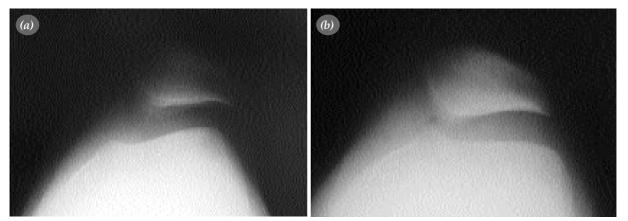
Pre-operative (a) and post-operative (b) patellofemoral axial radiographs of a patient with chronic patellar subluxation, who underwent lateral retinacular release and proximal realignment operations.
